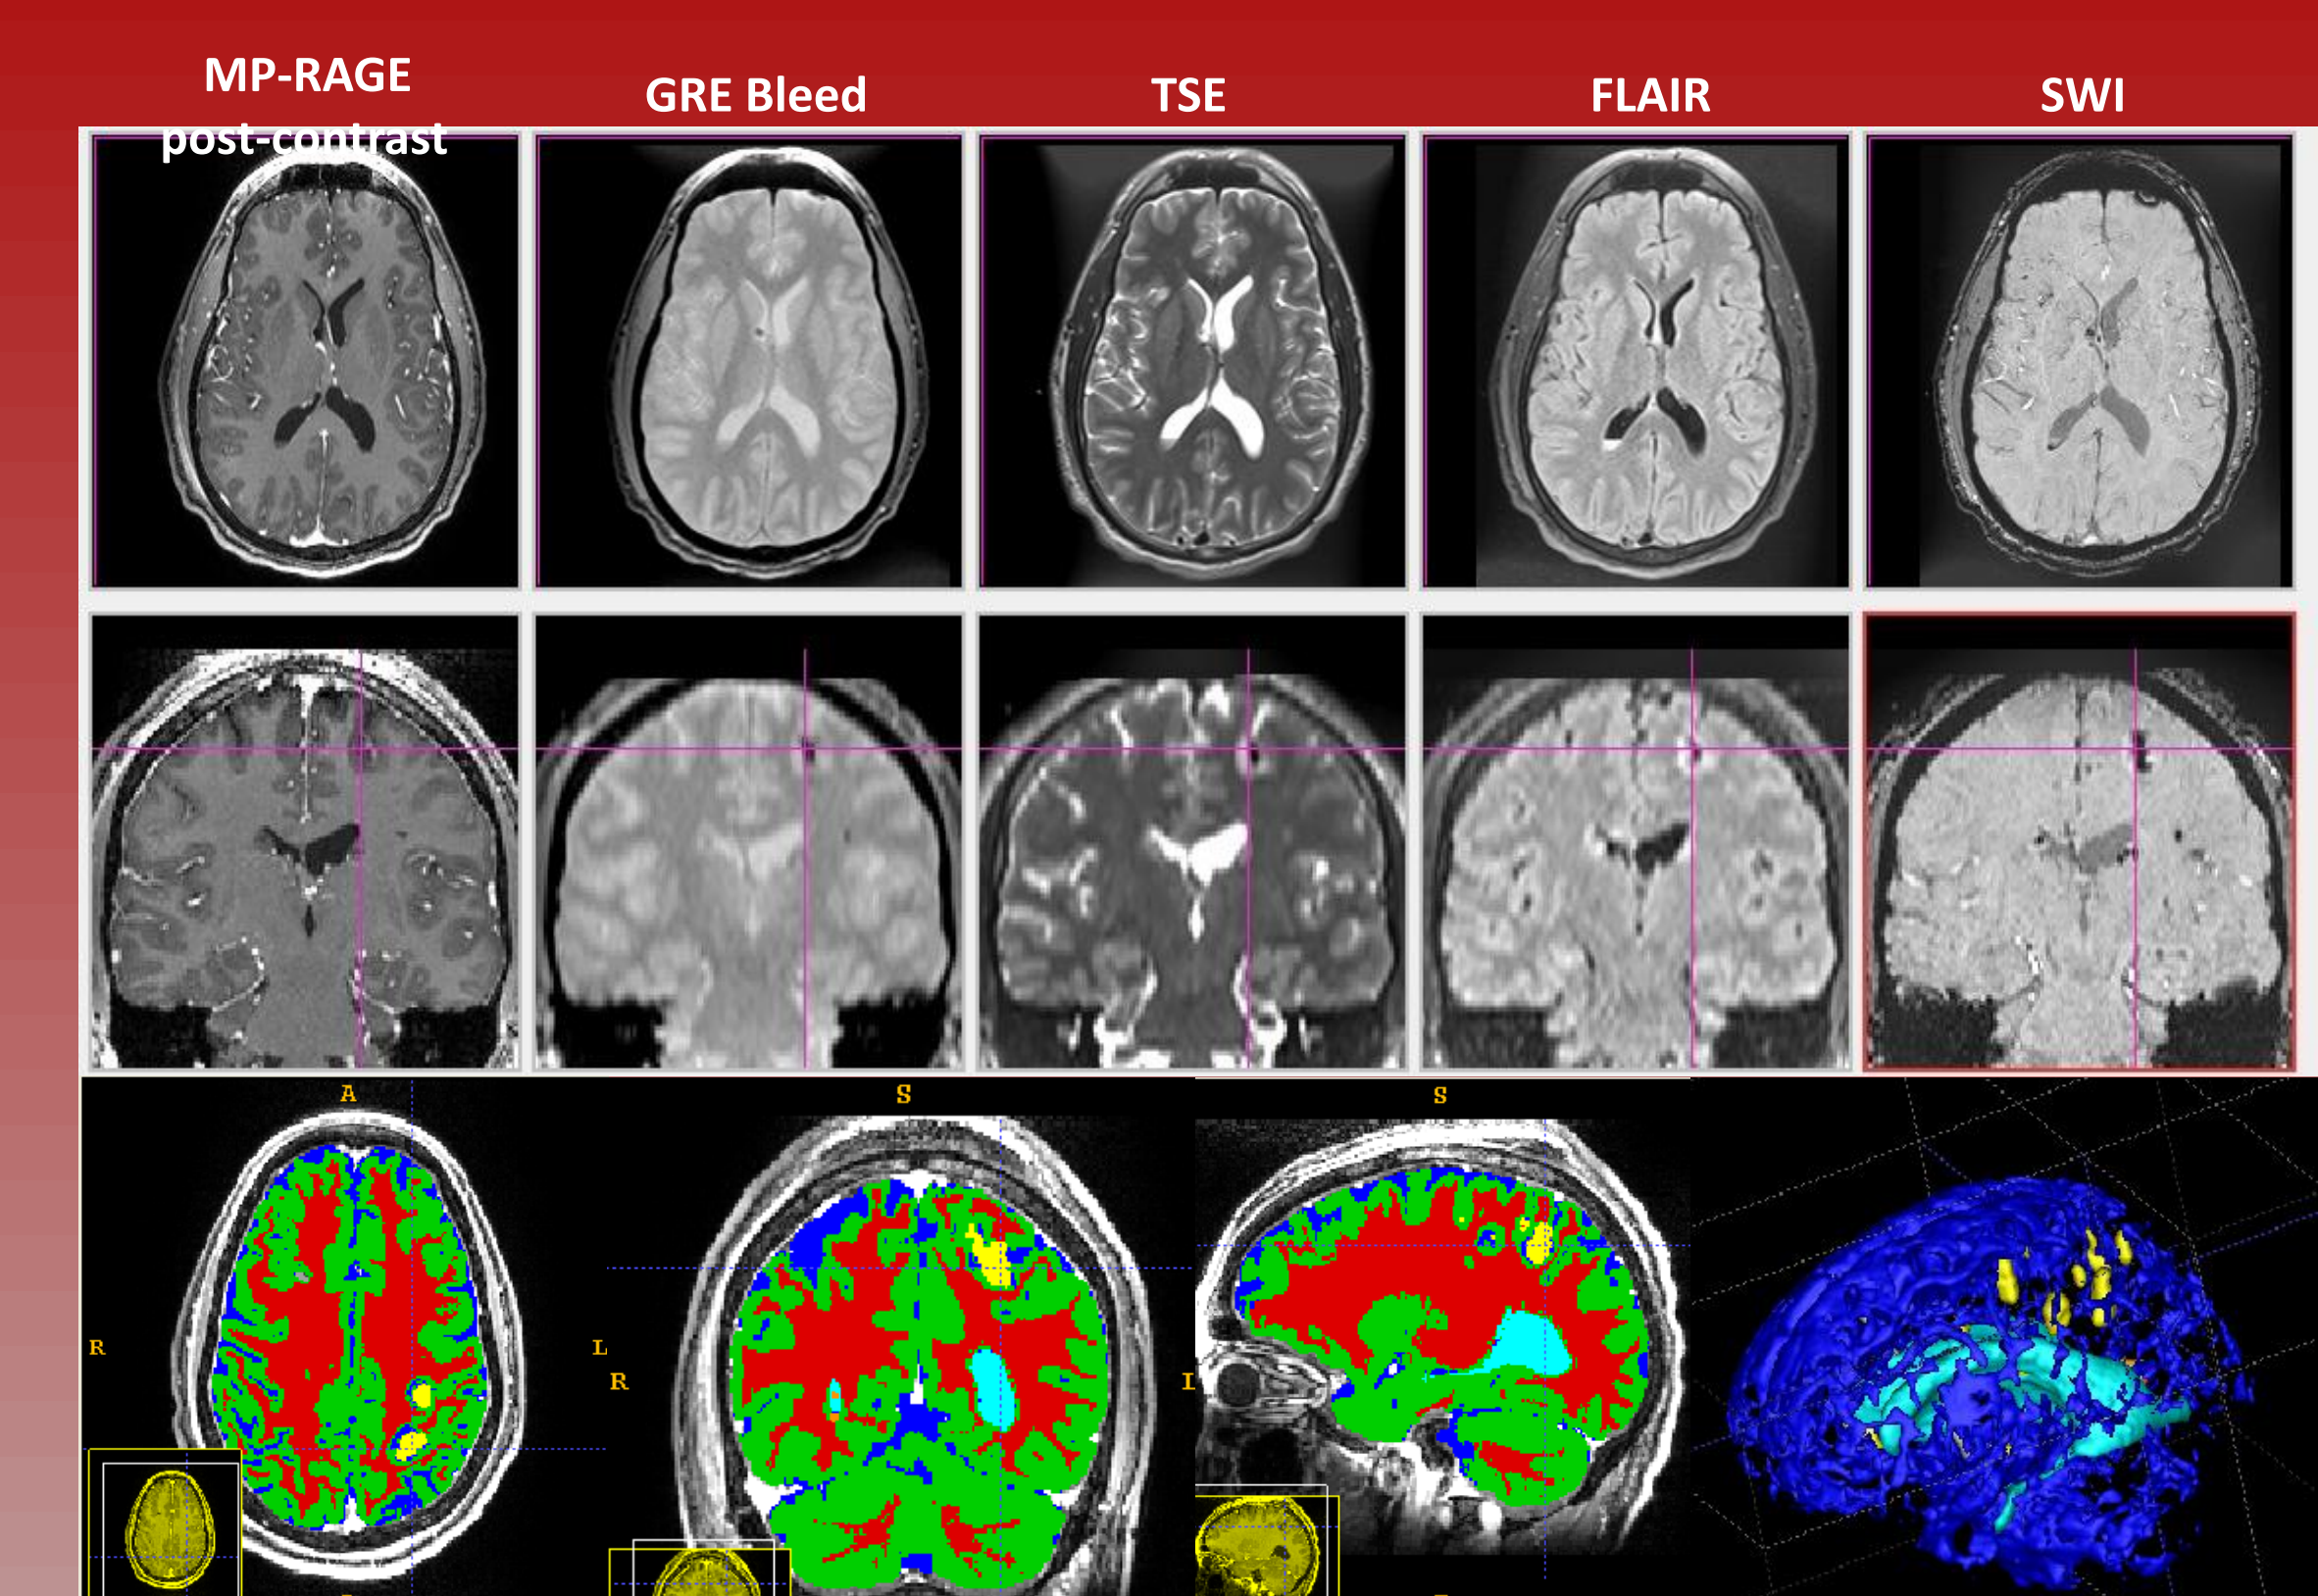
Multimodal segmentation of several MR volumes acquired from a TBI patient. The segmentation method being used (Atlas Based Classification, ABC) performs co-registration of all input modalities (5 MRI channels, in this case) and atlas-based segmentation of brain tissue and CSF. Bias-correction (all modalities) and brain-stripping is an integrative, automatic part of ABC. White matter lesions and ventricles were segmented via post-processing using level-set segmentation. (A) 5 MR image channels; (B) automatic tissue classification; (C) 3D model showing ventricles, lesions.
